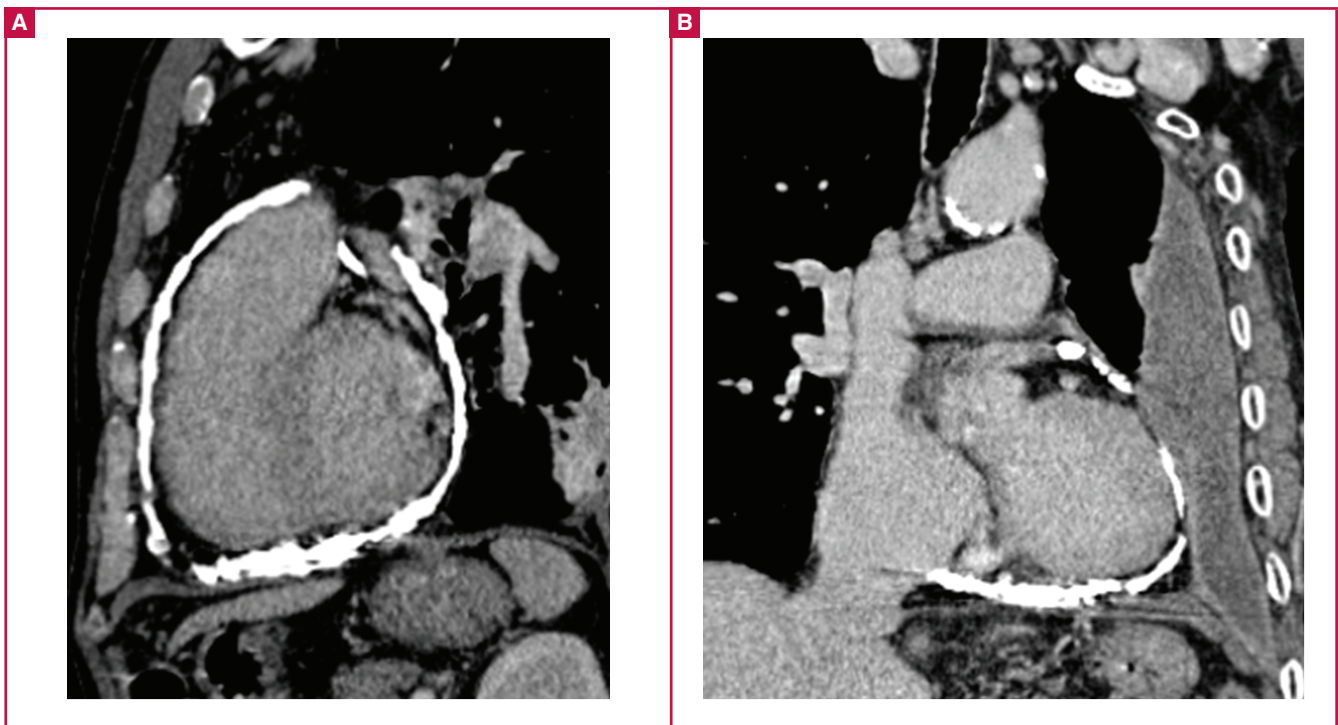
The pre-operative computed tomography scans acquired before the previous operation show a single layer of calcified pericardium enveloping the whole surface of the heart (A: sagittal plane; B: coronal plane).
